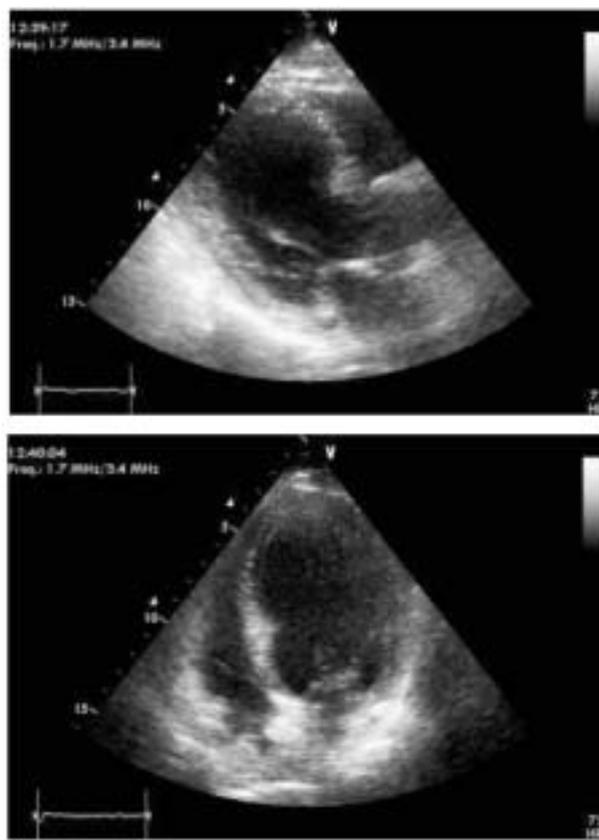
Echocardiographic findings on 4 October 2004. LVEDV=158 mL, LVESV=100 mL, end-diastolic diameter [DTD]=7.14 cm, end-systolic diameter [DTS]=5.21 cm, ejection fraction 38.4%, E-septum (distance between E point and septum in M-mode)=1.52 cm, left atrial area=21 cm<sup>2</sup>, wall motion score index=1.25.
